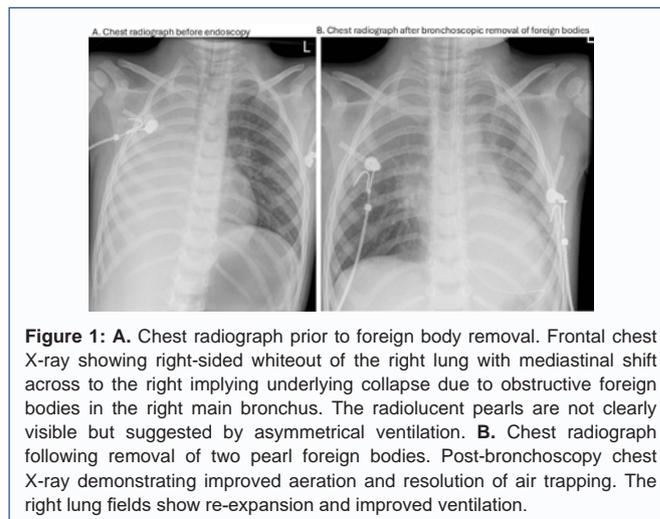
A. Chest radiograph prior to foreign body removal. Frontal chest X-ray showing right-sided whiteout of the right lung with mediastinal shift across to the right implying underlying collapse due to obstructive foreign bodies in the right main bronchus. The radiolucent pearls are not clearly visible but suggested by asymmetrical ventilation. B. Chest radiograph following removal of two pearl foreign bodies. Post-bronchoscopy chest X-ray demonstrating improved aeration and resolution of air trapping. The right lung fields show re-expansion and improved ventilation.
